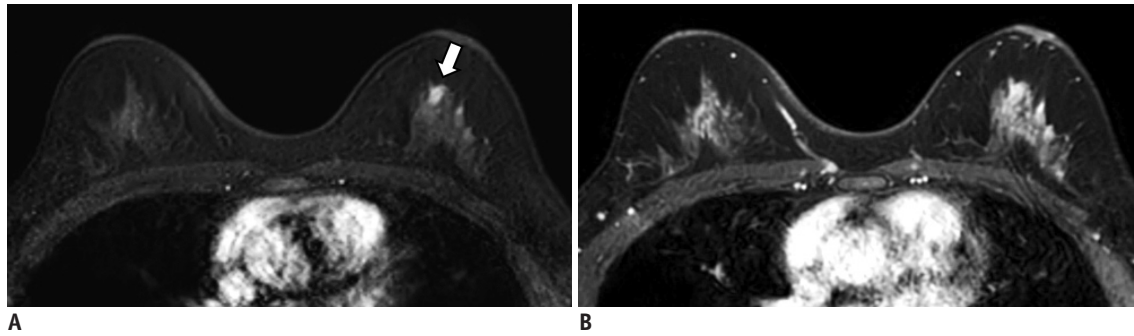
Preoperative breast MRI scanned using Ingenia (Philips Healthcare) in 51-year-old woman with better lesion conspicuity at ultrafast MRI.
